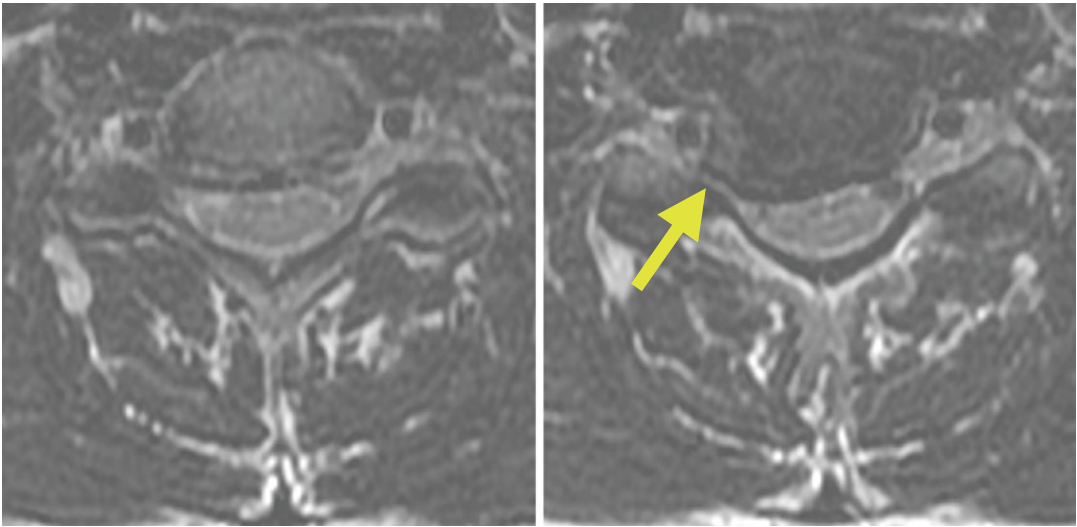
Axial T2-weighted images of the cervical spine demonstrating a right paracentral disk bulge (arrow)
